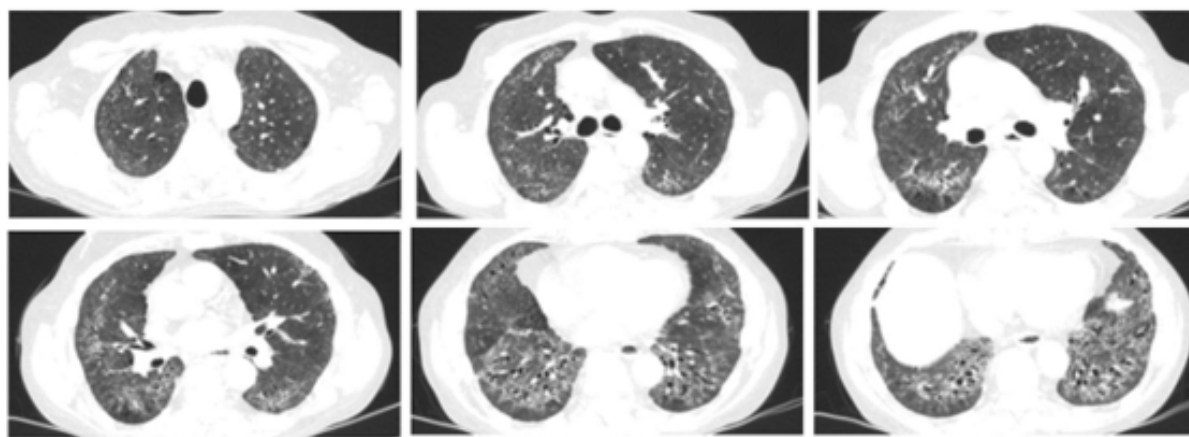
Axial HRCT images from 2021. demonstrate typical NSIP findings- reticulations, subpleural ground glass opacities and traction bronchiectasis.
